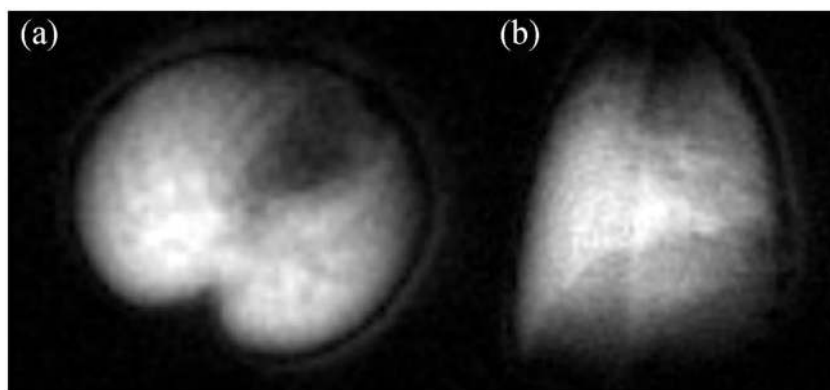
Post-mortem ^{19}F MRI of lung gas density using C_2F_6 . Axial images (a) were acquired within 2 min and coronal images (b) were acquired within 3 min using a 4.7-T magnet. These images show excellent quality similar to that obtained with hyperpolarized gases, although with much more accumulation.
